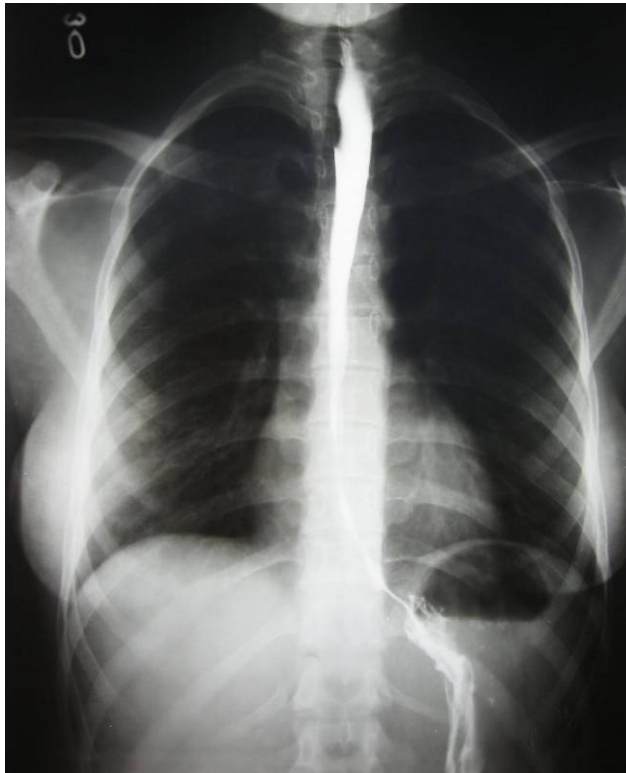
SD. Barium radiography. Hypokinesia of the esophagus.
